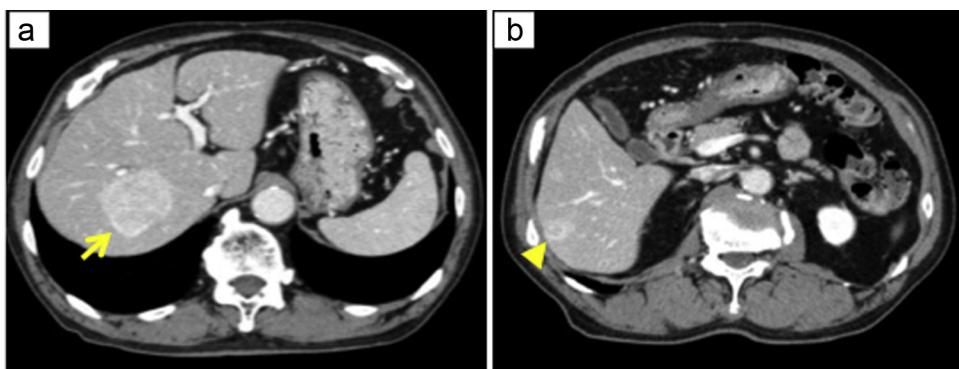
Finding of preoperative CT. CT showed a 5-cm HCC in segment 7–8 of the liver (arrow) (a) and a 2-cm HCC in segment 6 of the liver (arrowhead) (b).
